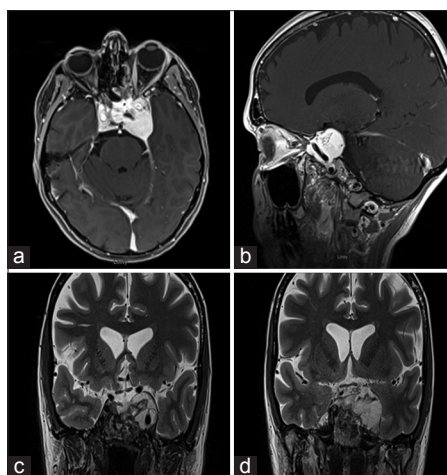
Postoperative imaging 5 months after tumor debulking. Axial (a) and sagittal (b) T1 magnetic resonance imaging with gadolinium and coronal T2 (c and d) showing stable tumor with no interval growth/progression
